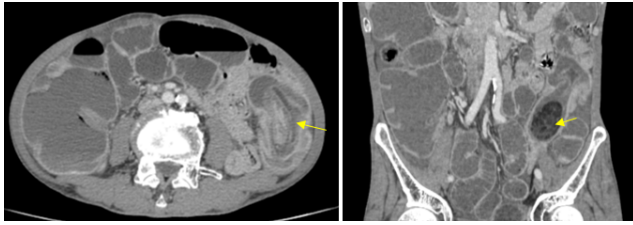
A 74-year-old male came complaints of abdominal pain and constipation since a week. Axial CT of the abdomen shows the presence of a bowel-within-bowel configuration, characteristic for intussusception. Coronal reformatted image shows lipoma as the lead point for colo-colic intussusception with proximal bowel dilatation
